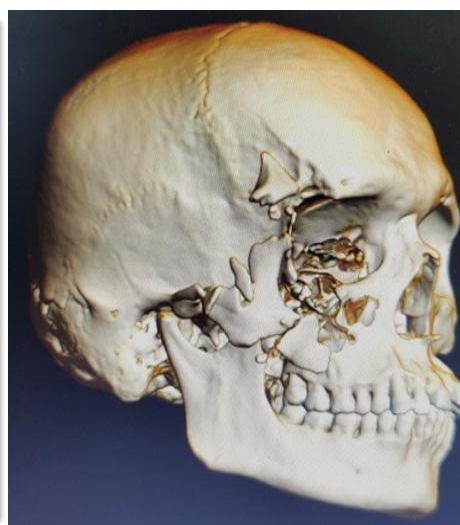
Pre-operative radiographic image
